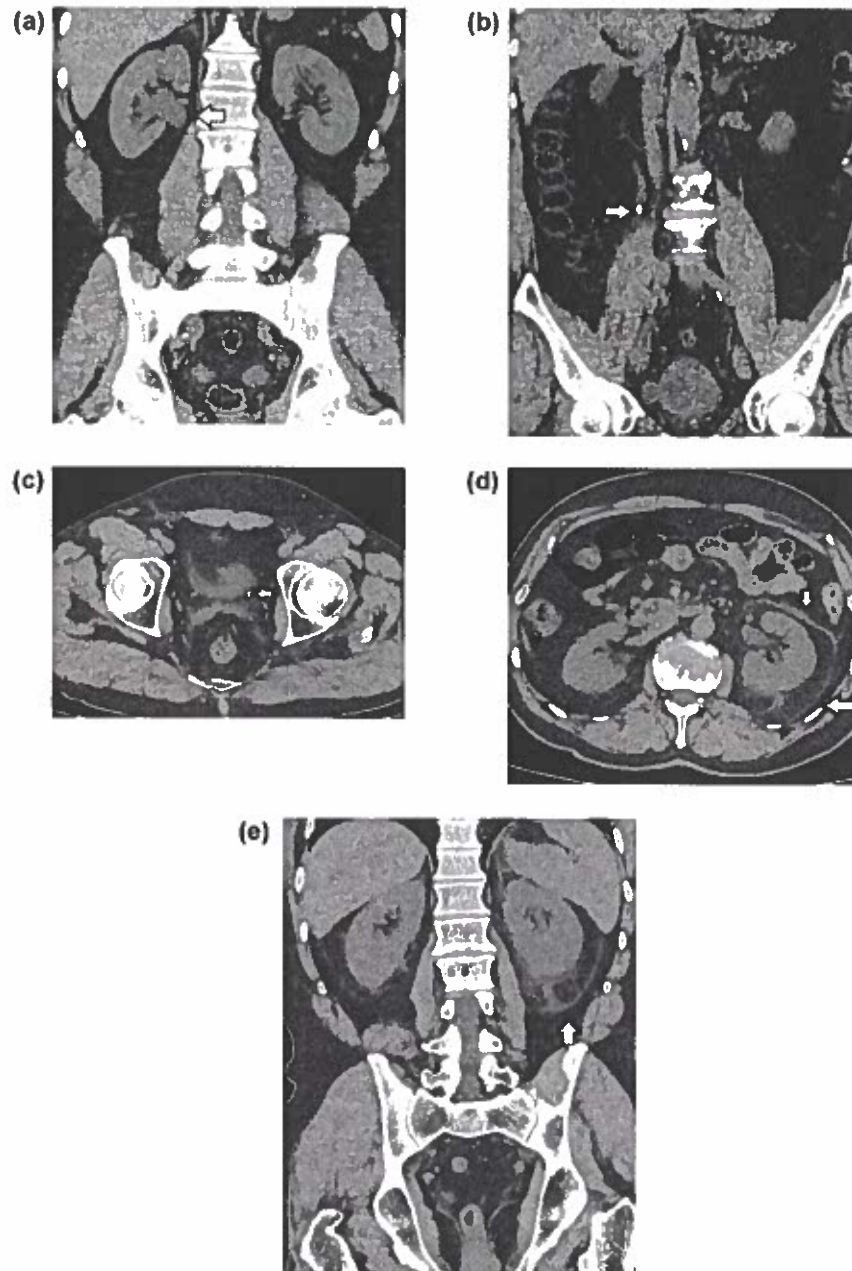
Typical non enhanced CT findings of ureterolithiasis in two patients. (a, b) Coronal reformations show a 4.5x6 mm stone (arrow, b) in the upper third of the right ureter, causing proximal ureteral dilatation and significant ipsilateral hydronephrosis (arrow, a). (c) Transverse image in the lower pelvis depicts a 2 mm stone (arrow) located in the left ureterovesical junction. (d) Axial and (e) coronal reformatted images in the same patient demonstrate secondary signs of ureterolithiasis, including thickening of the left renal fascia and perirenal septa (arrows), presence of fluid in the perirenal space and mild hydronephrosis.
